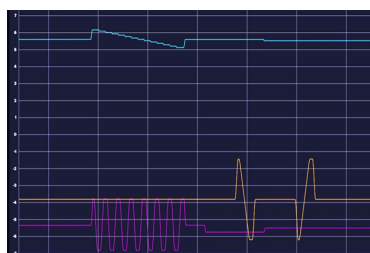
Event acquisition system. It collects and displays the operation of the X-axis (orange), Y-axis (magenta), and Z-axis (cyan) of the goniometer during 2D scanning using X-rays.
